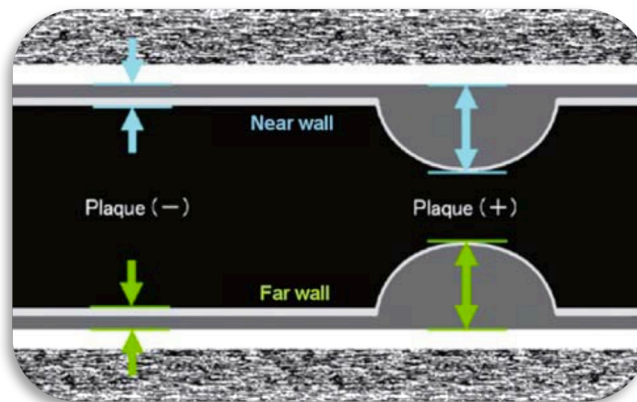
CIMT complex. Used with permission granted from the Terminology and diagnostic criteria committee of the Japanese society of ultrasonics in medicine (2009); Stein et al., 2009.
